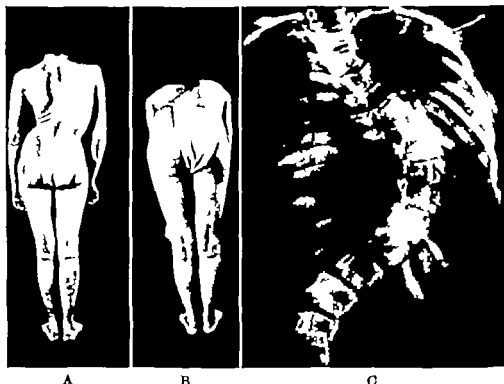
Severe right dorsal scoliosis. A, Patient in upright position. B, Patient in forward bent position. C, Roentgenogram of spine.
